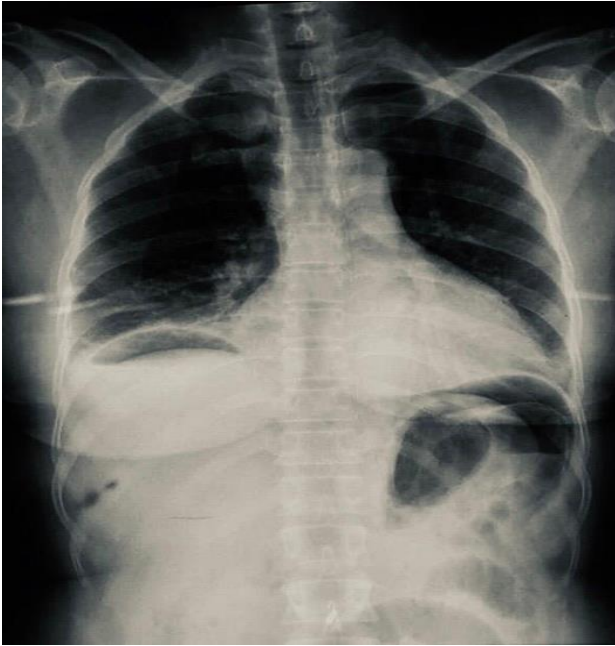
X-ray chest erect showing gas under both domes of diaphragm, establishing our diagnosis of perforation peritonitis.
